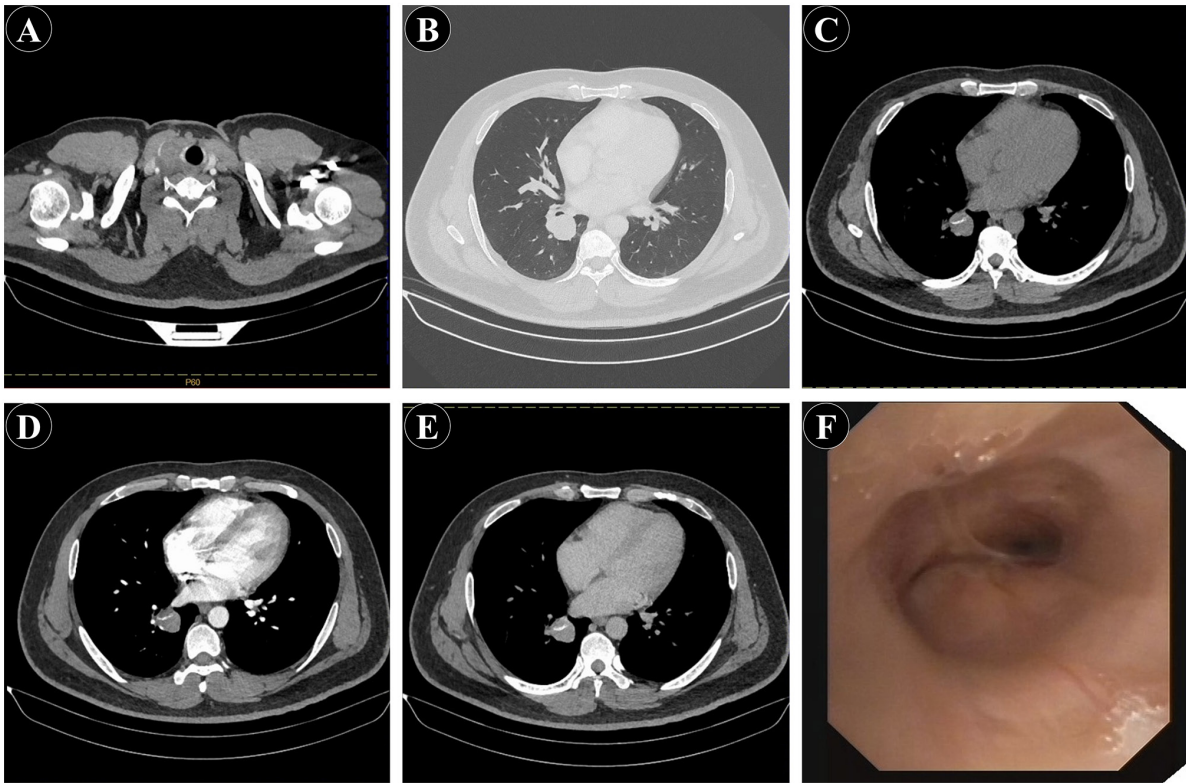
CT and bronchoscopy images. (A) Thyroid CT examination revealed a mass in the right lobe and a low-density lesion in the left lobe. (B) Chest enhanced CT scan in the lung window demonstrated a mass near the right lower lobar hilum measuring  $\sim 2.9 \times 2.3$  cm. (C) Chest CT scan in the mediastinal window displayed lesion attenuation ranging from 23 to 65 HU, with an average of 42 HU. (D) Arterial phase of the chest CT enhancement revealed lesion attenuation ranging from 16 to 53 HU, with an average of 36 HU. (E) Venous phase of the chest CT enhancement showed lesion attenuation ranging from 35 to 82 HU, with an average of 59 HU. (F) Intraoperative bronchoscopy revealed a smooth mucosa in the basal segment of the right lower lobe, with extraluminal compressive narrowing. CT, computed tomography; HU, Hounsfield unit.
